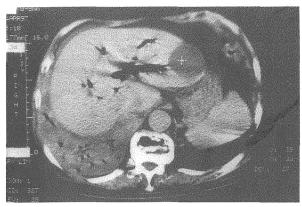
Abdominal computed tomography revealing pneumobilia and a dilated bile duct. There are some ascites accumulating between the liver and the right diaphragm, and one hepatic cyst is located in the left lobe. Gas-containing pleural effusion in the right hemithorax can be noticed.
